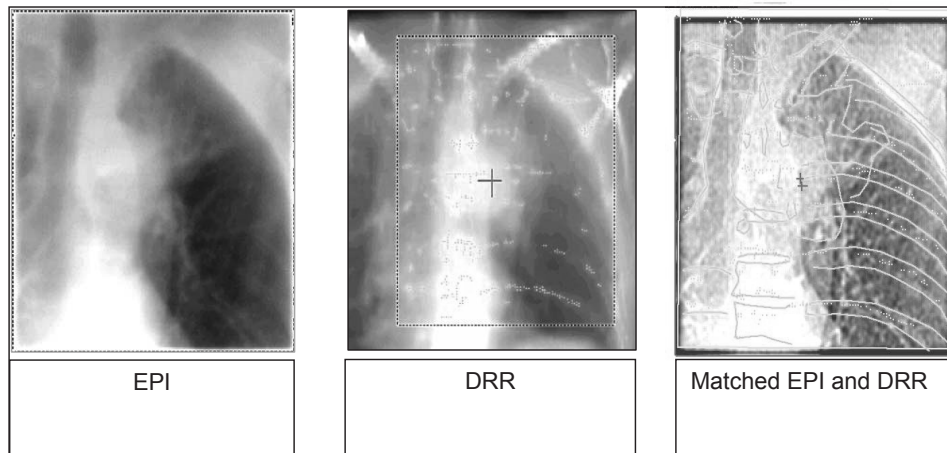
Match of the Electronic Portal Image (EPI) and the Digital Reconstructed Radiograph (DRR). The green dots are the contour tracing dots from the DRR, the green line representing the anatomy structure outline.
